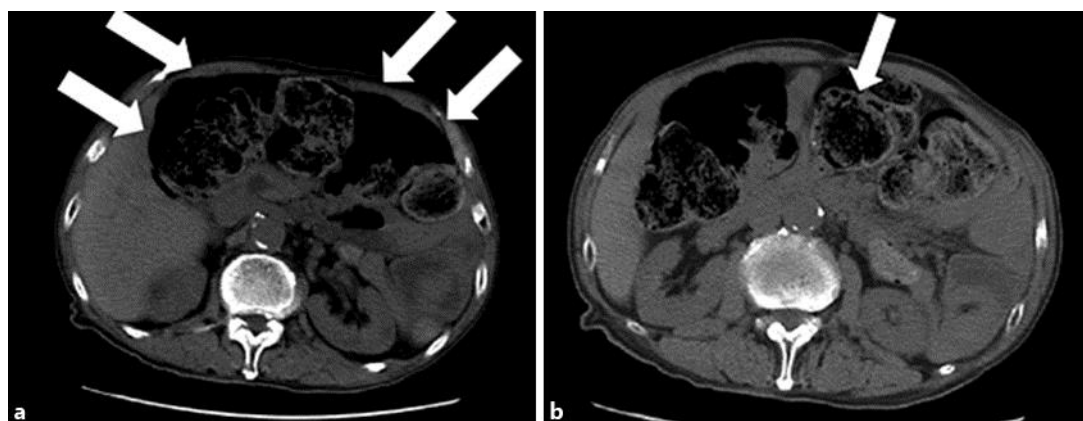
a Abdominal CT revealed a large amount of feces in the colon and rectum and free air in the abdomen (arrows). b Intestinal cystic pneumatosis was recognized in the colon (arrow).
